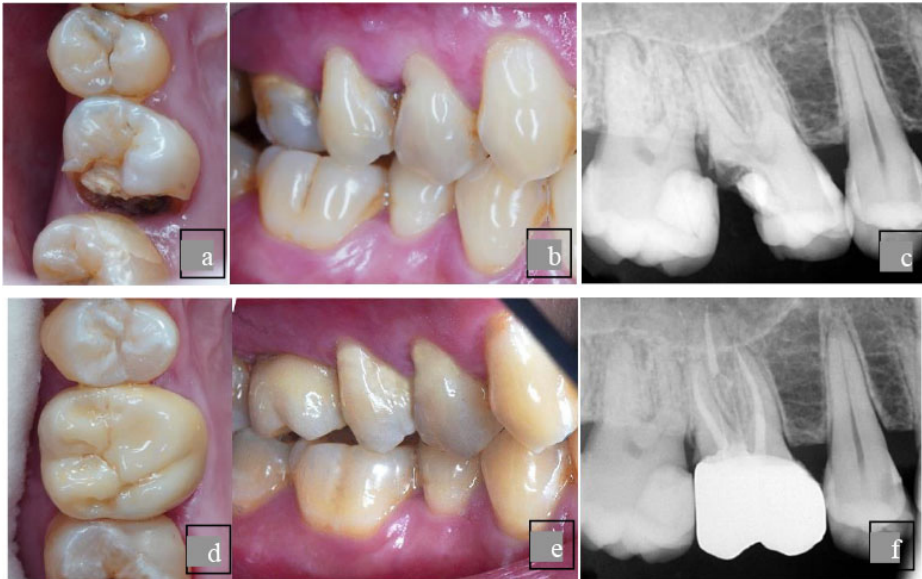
(a) and (b) Pre-Operative clinical image of right maxillary first molar (c) Pre-operative periapical radiograph showing radiolucency that extends disto-occlusal and has reached the pulp (d) and (e) Post-Operative clinical image endodontic treatment continued intentional inclination change with post-core crown restoration and (f) Post-operative periapical radiograph showing radiopaque images along the mesiobuccal and distobuccal canals and the apical 1/3 of the palatal root canal filled with gutta perca, 2/3 of the palatal root length was filled with fiberpost material. There was a radiopaque image on the crown showing a zirconia crown restoration.
